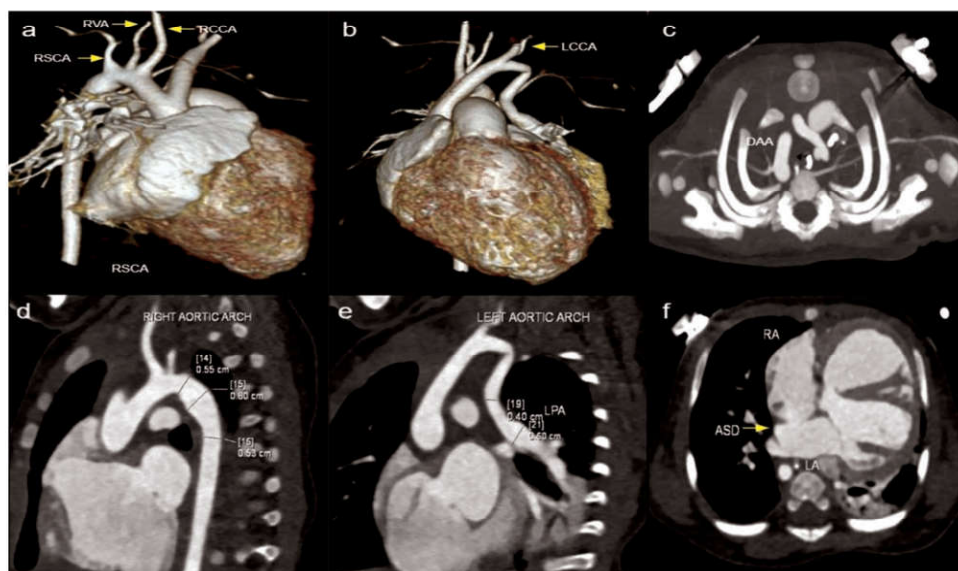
CT chest contrast and VRT images showing double aortic arch with RSCA, RCCA and RVA arising from the right arch continuing as descending aorta, and LCCA arising from the left arch. Note is also made of ASD (Atrial septal defect).
